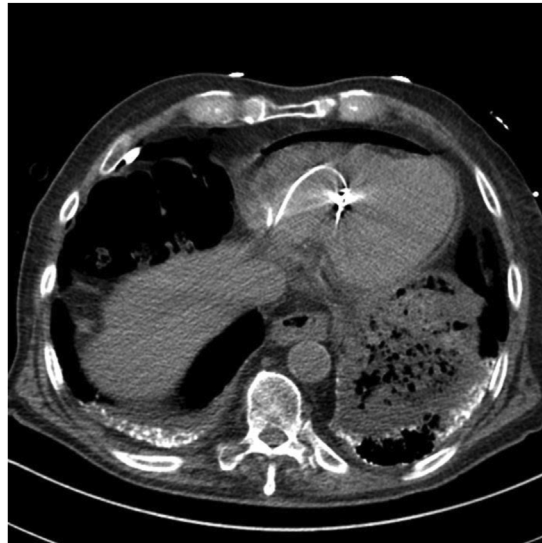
Computed tomography of the chest with pneumoperitoneum and atrial lead position.
